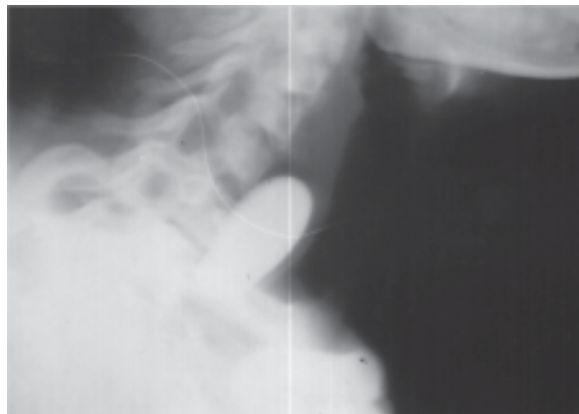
X-ray Neck lateral view showing F.B Stone upper end of esophagus.
